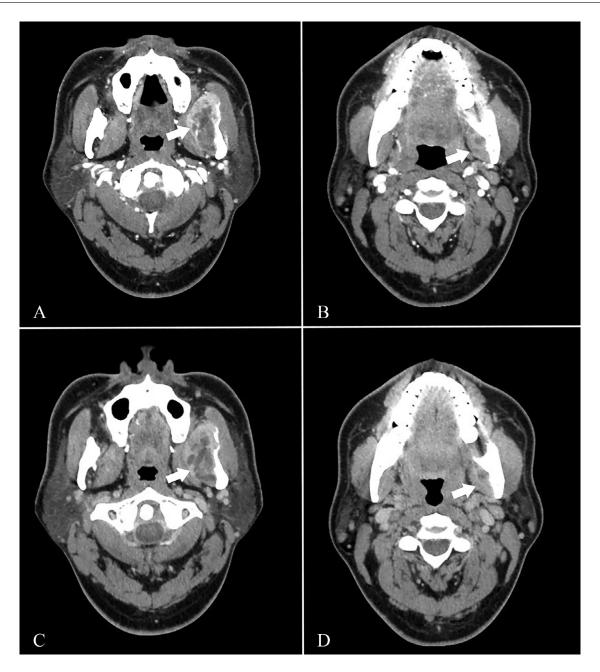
Arterial phase (A-B) and venous phase (C-D) CT images, soft-tissue window (window width: 300HU, window level: 35HU). A massive lesion straddled the left mandibular ramus (arrows in A, C) and angle (arrows in B, D). A poorly-defined soft tissue mass with cystic components in it.
